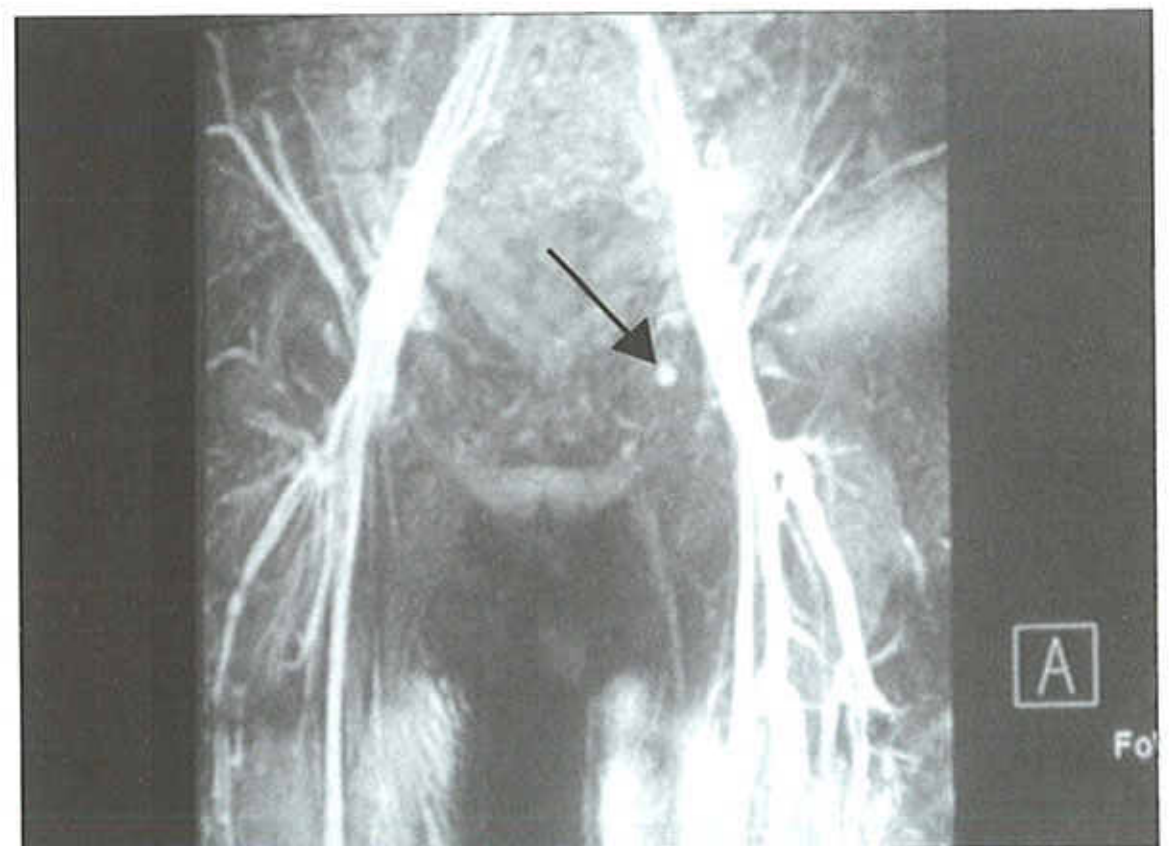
MRI. The number of the lymph nodes in both inguinal regions markedly decreased.
